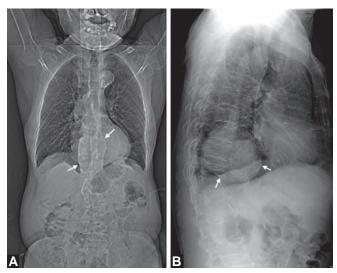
Scout CT image of chest: (A) Shows prominent descending aorta raising a suspicion of aneurysm. Aortic reconstruction following contrast CT of chest and abdomen; (B) Shows no aneurysm but only tortuous and elongated dilatation of thoracic aorta (arrow)
